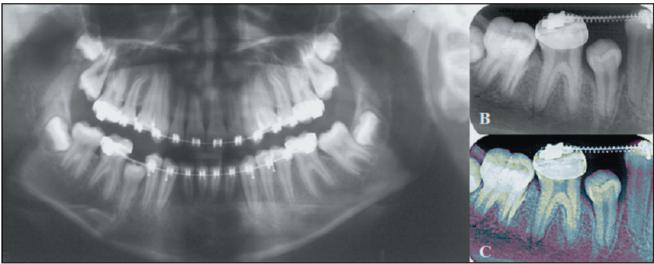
One-year postoperative panoramic (a), periapical conventional (b), and digitized electronically processed (C) radiographs demonstrating good bone formation and substantial eruptive movement of the right inferior second premolar.
